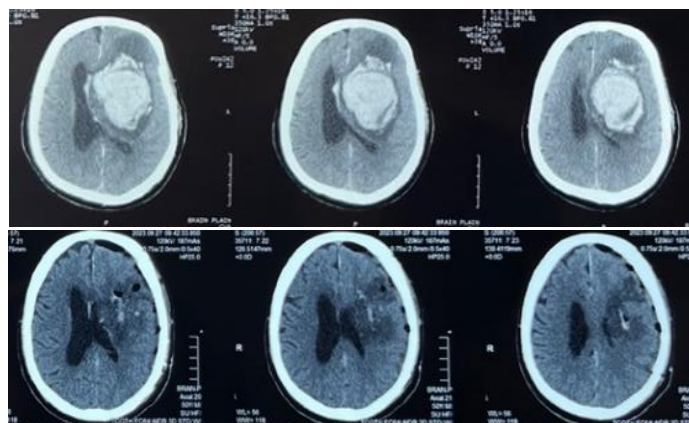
Pre and post-operative CT scan of Left Intra-cerebral bleed
